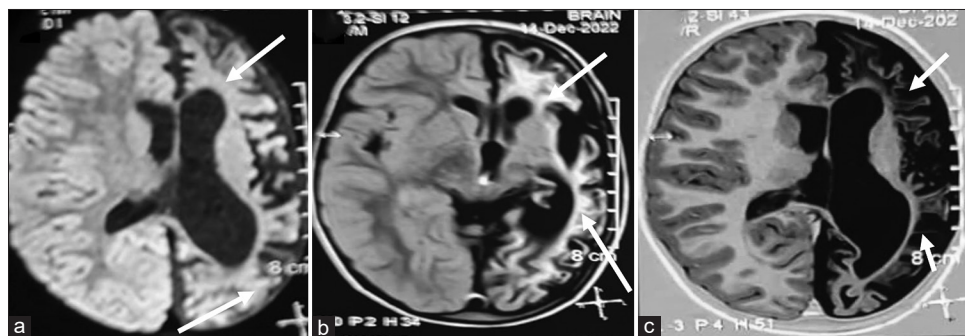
(a-c) Repeat magnetic resonance imaging brain at 4 years. Axial diffusion weighted sequence showing left hemisphere atrophy (thick white arrows) with no restricted diffusion. Diffuse gliotic areas in the left cerebral subcortical white matter appearing hyperintense on axial fluid-attenuated inversion recovery and hypointense (thin white arrows) on T1-weighted sequences.
